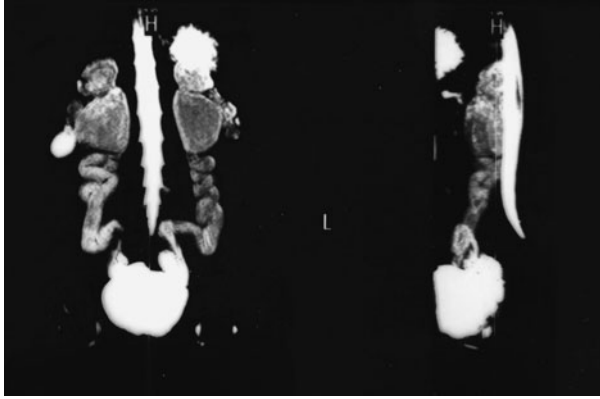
Magnetic resonance image of urinary tract in a five-year-old boy, born with posterior urethral valves ablated shortly after birth: the pyelocaliceal system remains bilaterally dilated, with ureters enlarged and tortuous.
